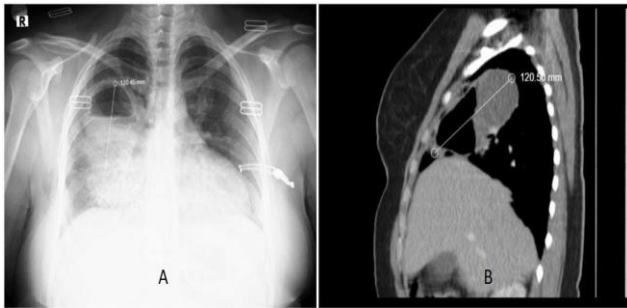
Pulmonary abscess with a diameter of 12x6 cm; A: posterior-anterior chest radiograph, B: computerized tomography
